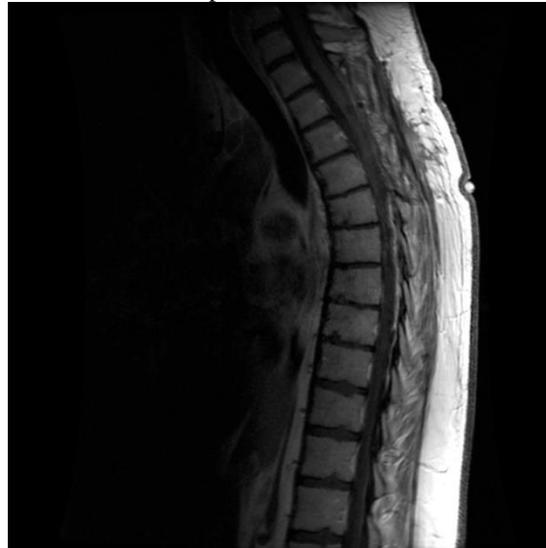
Pre-operative sagittal T2 MRI demonstrating T3-5 intramedullary lesion with cord expansion and significant edema extending cranially and caudally.
